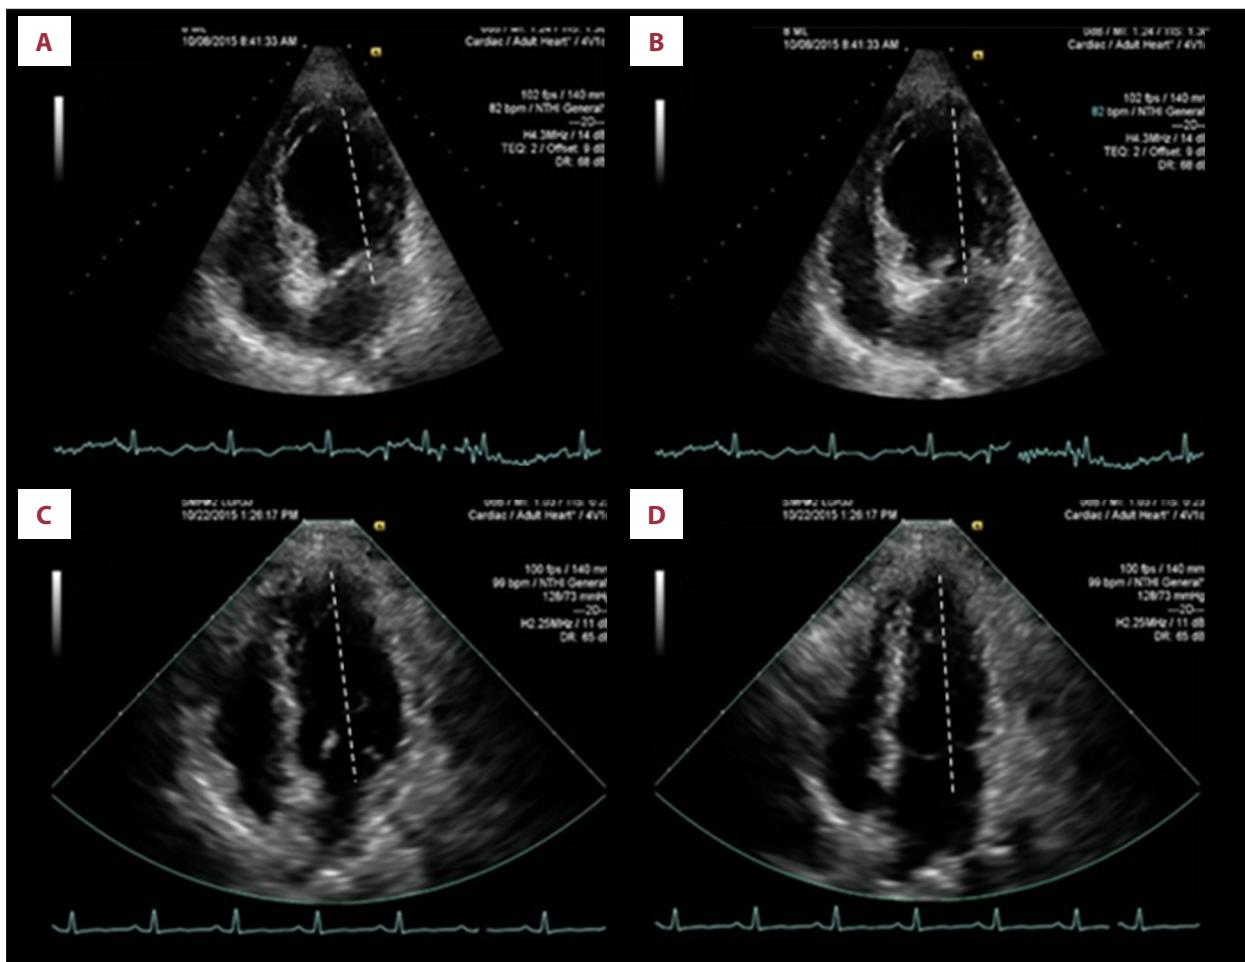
Transthoracic echocardiogram (apical 4-chamber view) showing apical and midventricular hypokinesis and normal contracting apex at the end of diastole (A) and at the end of systole (B). Repeat transthoracic echocardiogram 2 weeks after the initial presentation shows normalization of contraction of all segments of left ventricle. (Dotted lines to better visualize lack of shortening in A and B).
